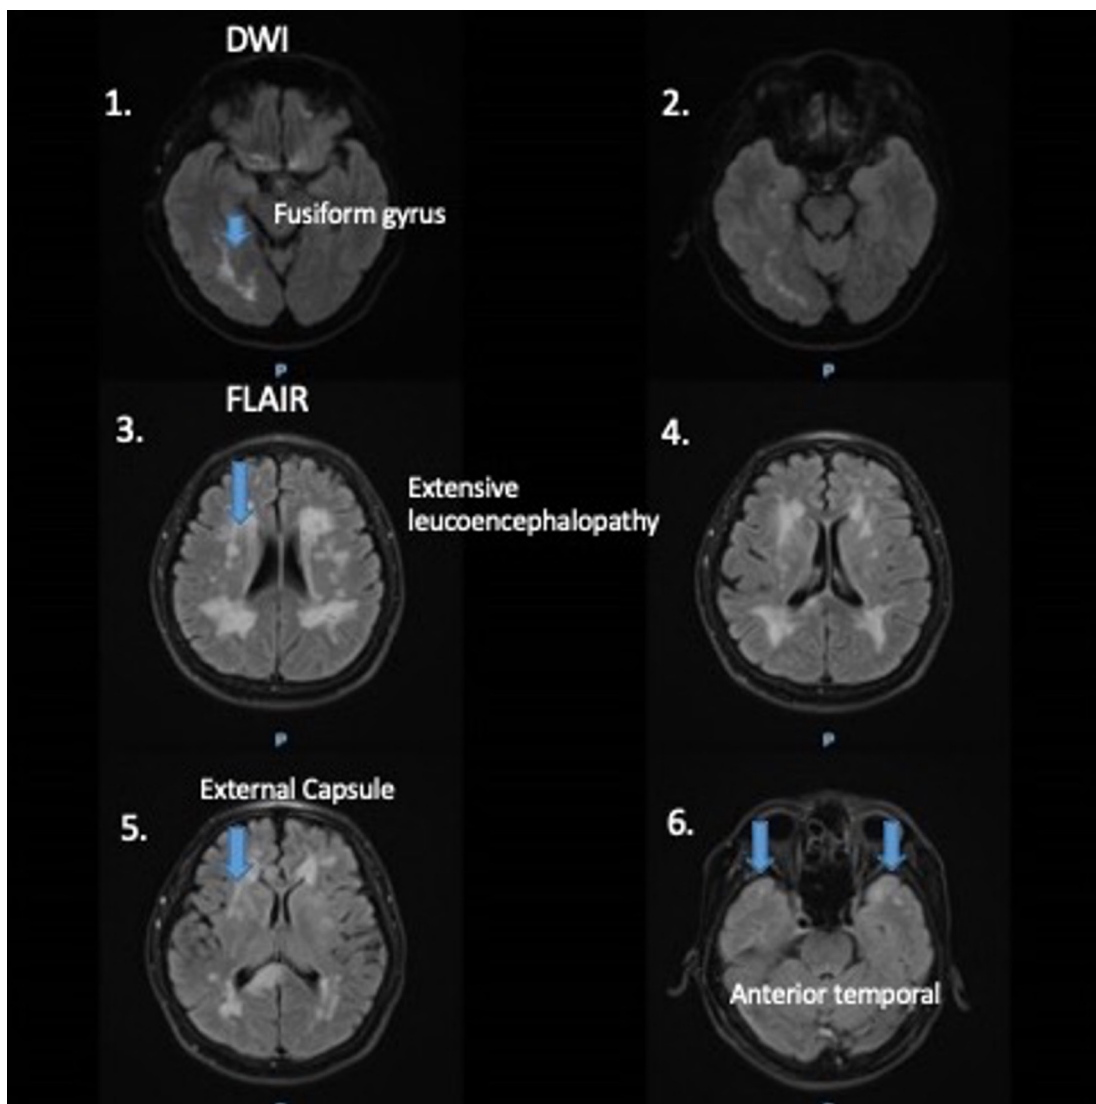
1&2: Diffusion imaging showed restricted diffusion over the right fusiform gyrus. 3&4: T2 weighted FLAIR MR imaging showed extensive subcortical white matter changes. 5. T2 weighted FLAIR MR imaging showed hyperintensity of the right external capsule. 6. T2 weighted FLAIR MR imaging showed hyperintensities of bilateral anterior temporal lobes.
